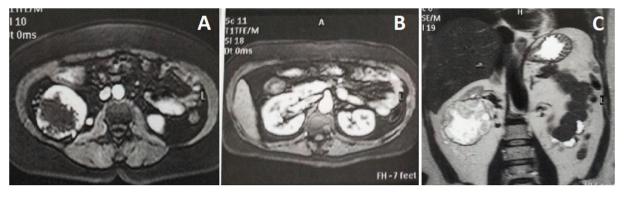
Abdominal magnetic resonance imaging with expansive lesion involving the lower and middle thirds of the right kidney measuring $7.2 \times 7.2 \times 7.3$ cm in its largest diameters (estimated volume of 189.2 cm3), with an extensive area of necrosis/liquefaction of probable neoplastic etiology (A). The lesion shows signs of invasion of the fat from the right renal sinus, in addition to presenting an exophytic component that does not clearly invade the right perirenal fat (A and B). Mild parietal thickening in the terminal ileum, cecum and ascending colon, without signs of restricted diffusion, with mucosal enhancement, with a nonspecific aspect (C).
